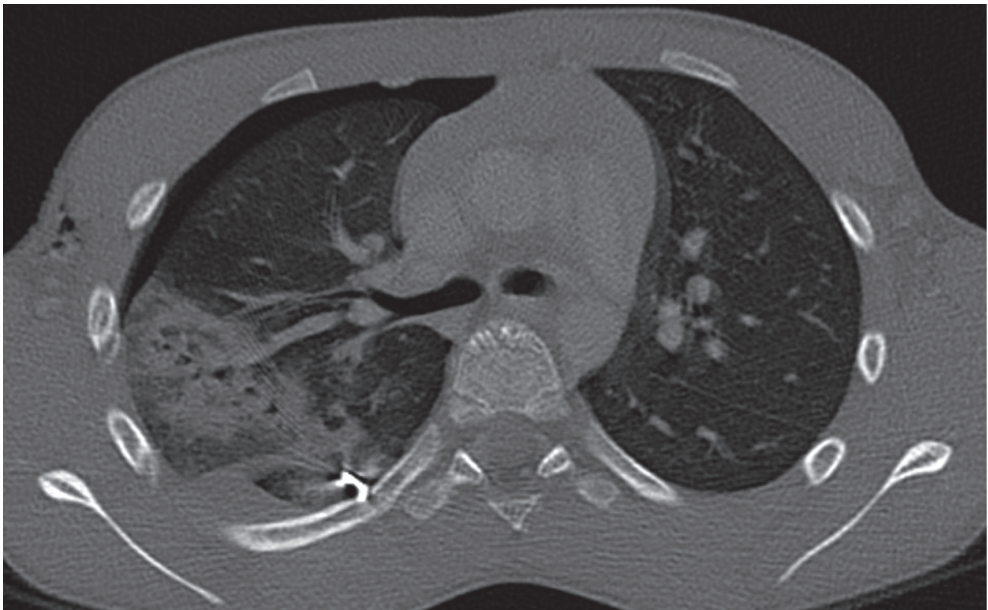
CT with an improvised explosive device-like trajectory through the lung parenchyma.
